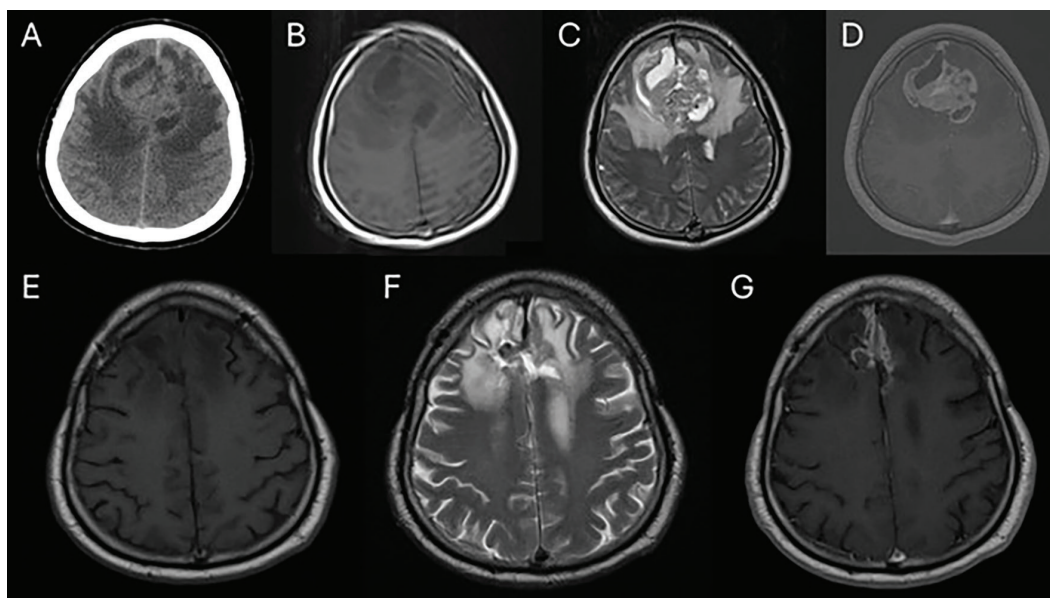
Preoperative (A-D) and postoperative (E-G) images of the first surgery. A: Cranial CT scan shows the frontal lobe lesion. T1-weighted (B), T2-weighted (C), and contrast-enhanced T1-weighted MRI (D) show the frontal mass. Postoperative MRI images [T1-weighted (E), T2-weighted (F), and contrast-enhanced T1-weighted magnetic resonance images (G)] show the postoperative surgical field
